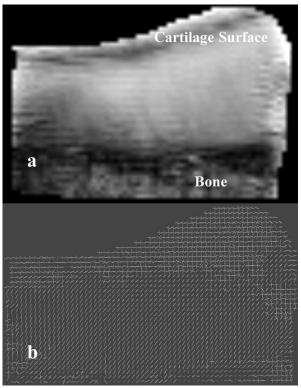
(a) T2 MR image; (b) fiber orientations (cartilage).
